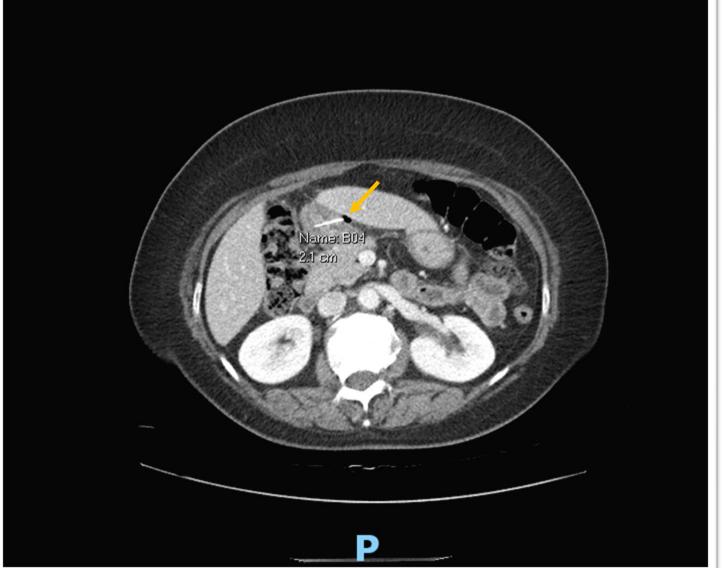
Abdominal CT, axial view. Orange arrow shows radiolucency suggestive of gastric antrum perforation and adjacent pneumoperitoneum.
